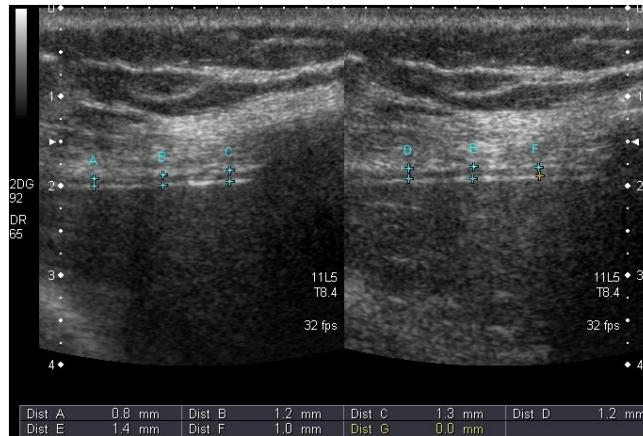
(A) Sonogram of the diaphragm during expiration and (B) inspiration.
